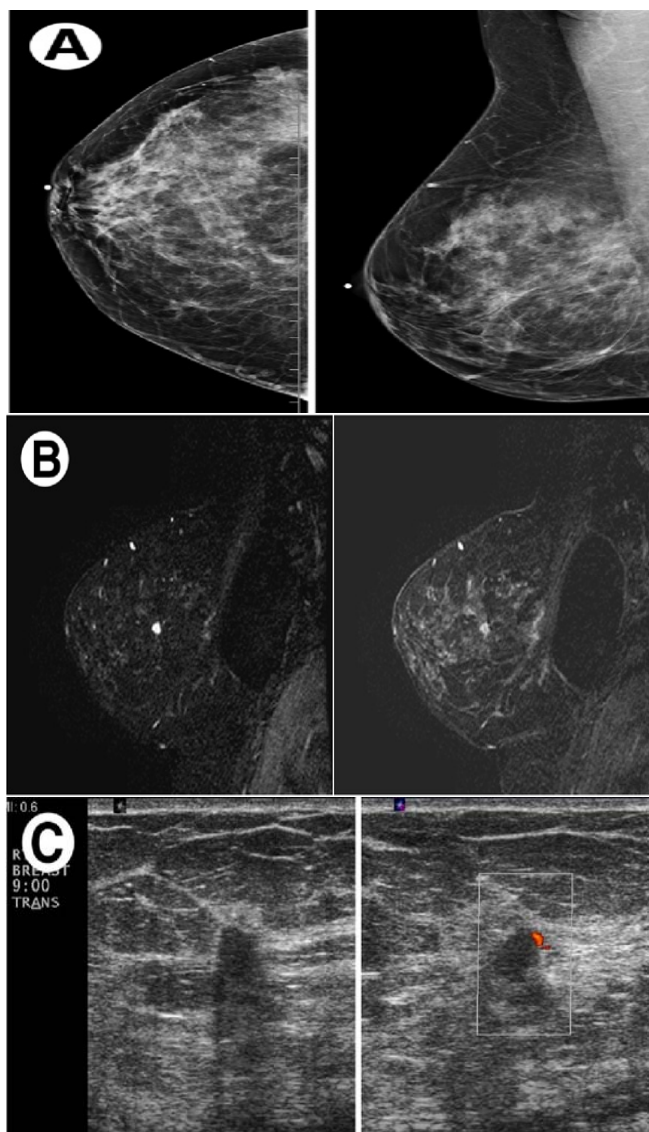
(A) Annual mammography screening done upon a 59-year-old woman with a strong family history of breast cancer. No suspicious mammographic findings were identified. (B) Then the patient went through MRI screening on the same day and a 8-mm suspicious mass at the 9-o'clock position was found using MRI screening. (C) Later on transverse grayscale and power Doppler ultrasound images of the right breast in the 9-o'clock region show a corresponding 7-mm irregular mass with peripheral vascularity. Then Ultrasound-guided biopsy was performed, revealing evidence of invasive ductal carcinoma [4].
